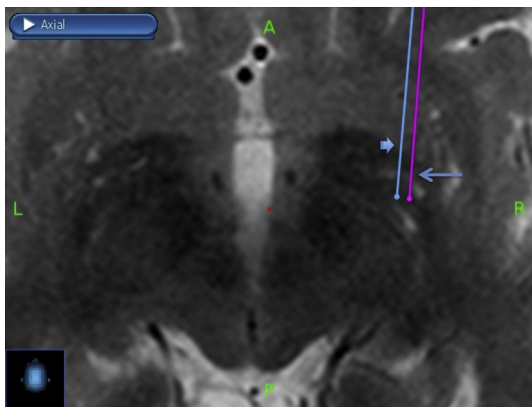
Axial MRI showing the planned trajectory target (small arrow head), and the microelectrode tract (long arrow) during a right Gpi DBS implantation surgery. The difference in the axial plane is the basis for the calculation of radial error.
